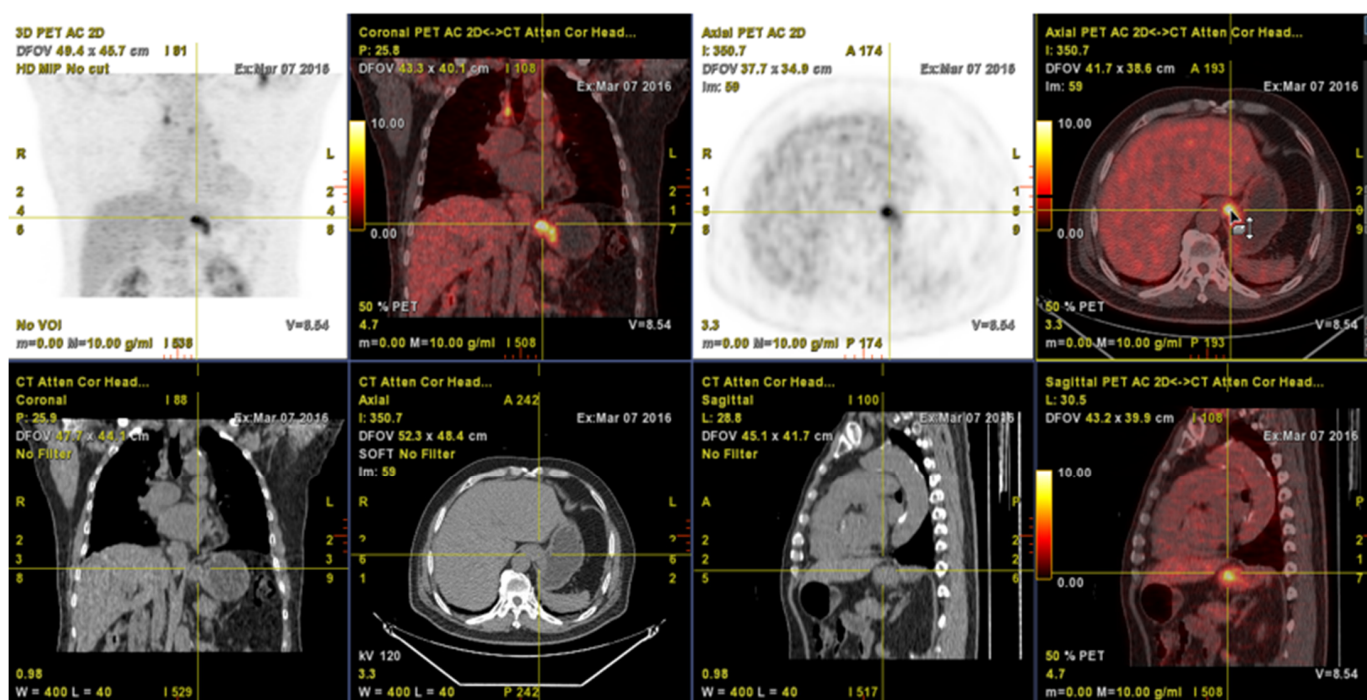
A 78 y/o male patient was diagnosed cT2N0M0, stage II on pre-treatment ^{18}F -FDG PET/CT. The small tumor mass with FDG hot uptake was noted on ^{18}F -FDG PET/CT (yellow color cross indicator). Metabolic parameters showed SUVmax: 7.61, SUVmean: 4.65, MTV: 11.07 cm^3 , and TLG: 51.41 $\text{g}/\text{mL cm}^3$ by the PET VCAR. He underwent CRT treatment and expired 3.9 months later due to disease progression.
